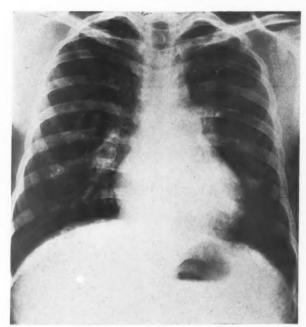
Roentgenograms of the chest.
